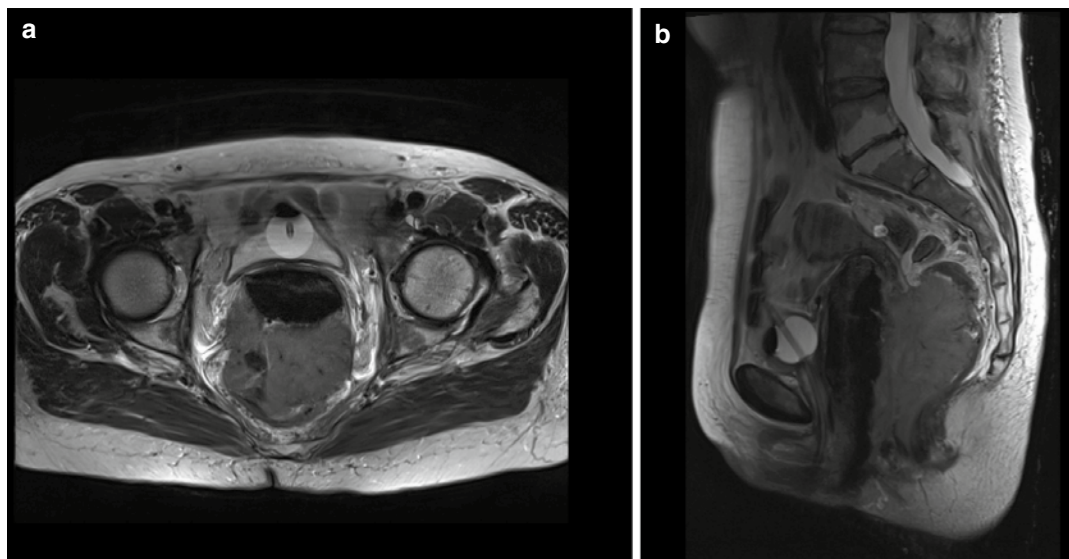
oT4 vaginal carcinoma infiltrating the rectum. T2-weighted transverse (a) and sagittal (b) MRI scans show a large tumor of the dorsal vagina extending over a distance of more than 10 cm into the rectum
